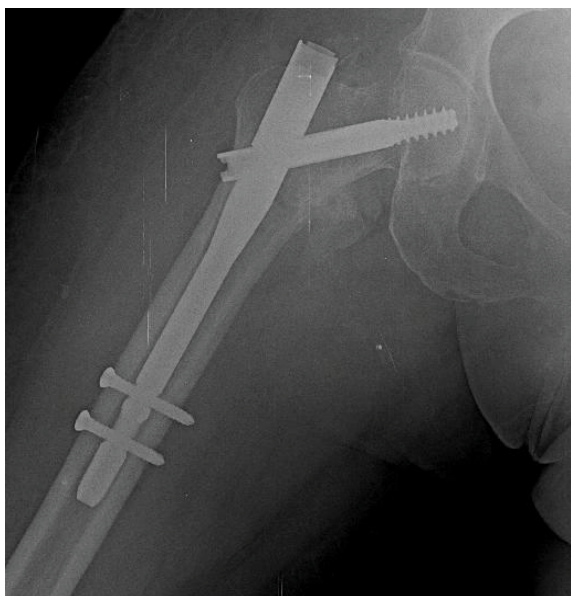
Anteroposterior radiograph of right hip with natural nail in situ
